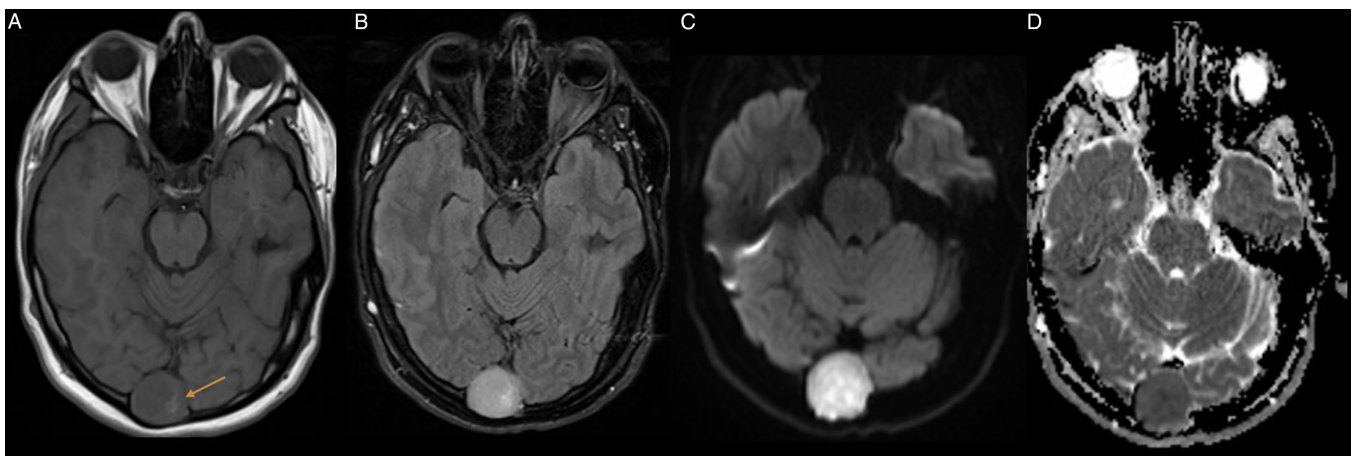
MRI of the brain. a) Axial T1 pre contrast shows intradiploic occipital mass with low signal intensity and peripheral linear high signal could be blood, calcification, or proteinaceous material (Arrow). b) Axial FLAIR lesion shows high signal intensity. c) and d) Axial DWI and ADC show restricted diffusion.
